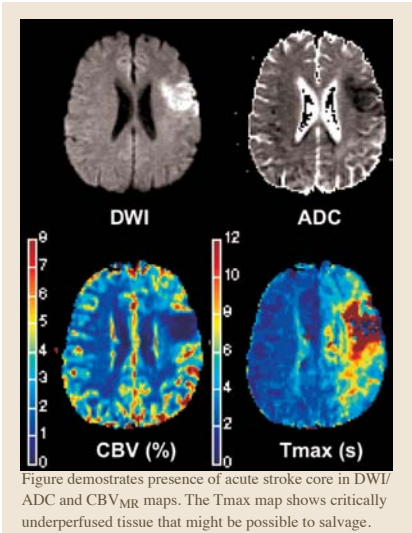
Figure demonstrates presence of acute stroke core in DWI/ADC and CBV_{MR} maps. The Tmax map shows critically underperfused tissue that might be possible to salvage.
